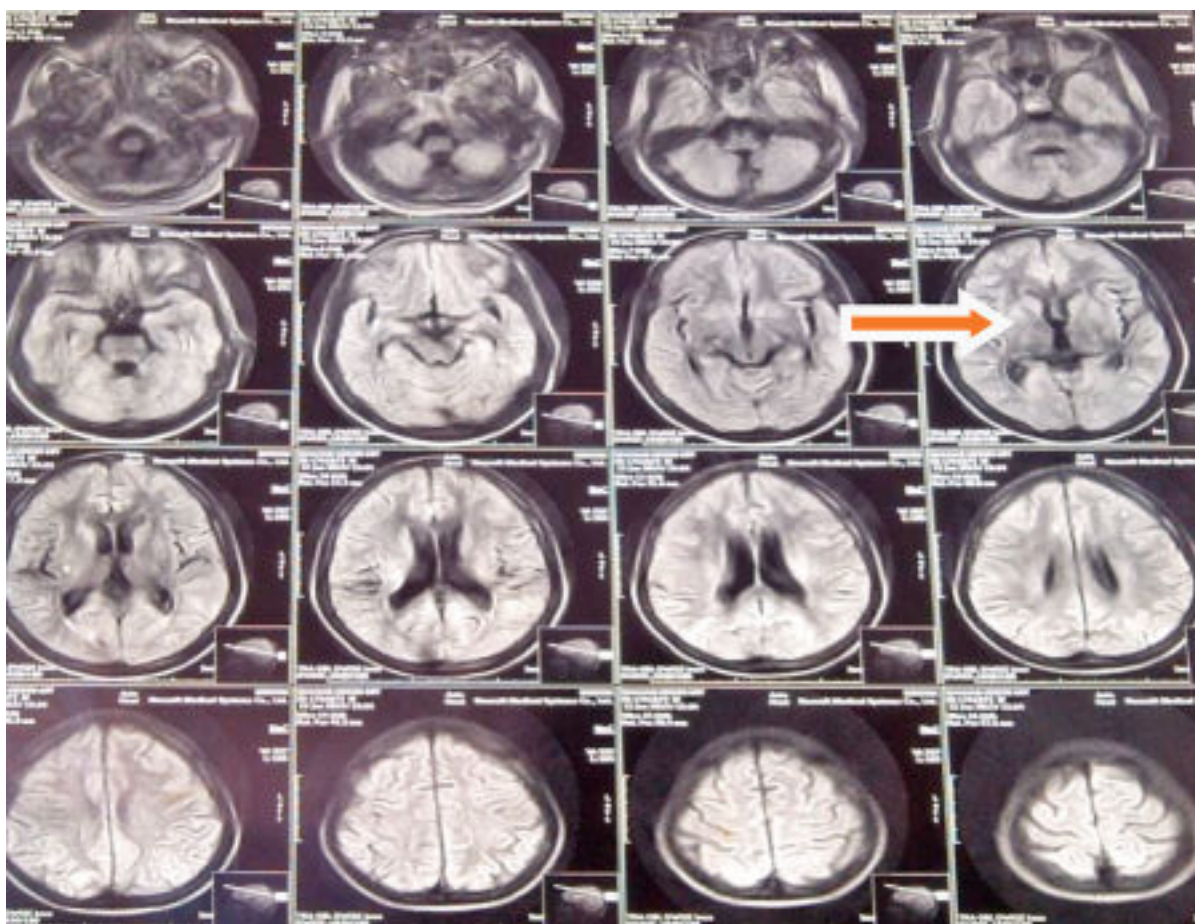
MRI brain (DWI) showing brainstem infarct (arrow)
